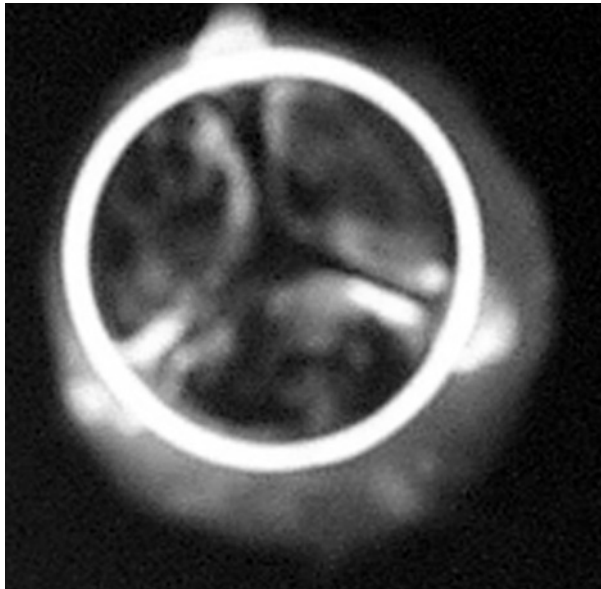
X-Ray examination of the removed valve revealed remarkable calcification observed almost uniformly in all leaflets.
